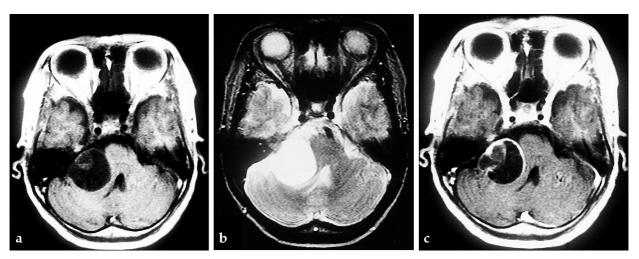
Pre-operative brain MRI showing the tumor. It was attached to the right CPA, and showed heterogenous, ring-shaped enhancement with GdPA. (a. T1 weighted image, b. T2 weighted image, c. T1-GdPA image).
